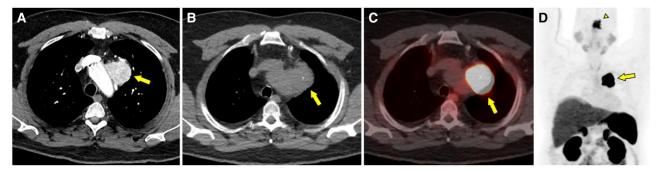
Paraganglioma imaging studies. (A) Chest CT with intravenous contrast revealed a heterogeneously enhancing left anterior mediastinal mass (arrow) measuring 4.7 cm with central punctate calcification. (B, C) The mediastinal mass (arrow) exhibited intense uptake with ⁶⁸Ga-DOTATATE PET/CT. (D) In the maximum intensity projection, increased DOTATATE activity was observed in both the mediastinal (arrow) and sellar (arrowhead) masses.
